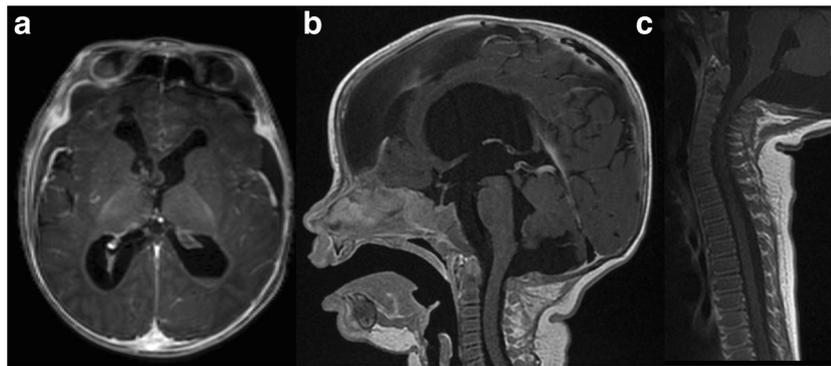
Follow-up brain and spinal MRI, immediate postoperative (a) and at 1 month of follow-up (b, c). a Immediate postoperative MRI (24 h). Axial TFE with gadolinium shows removal of the mass with postsurgical changes in the foramen of Monro. b 1-month follow-up brain MRI.
